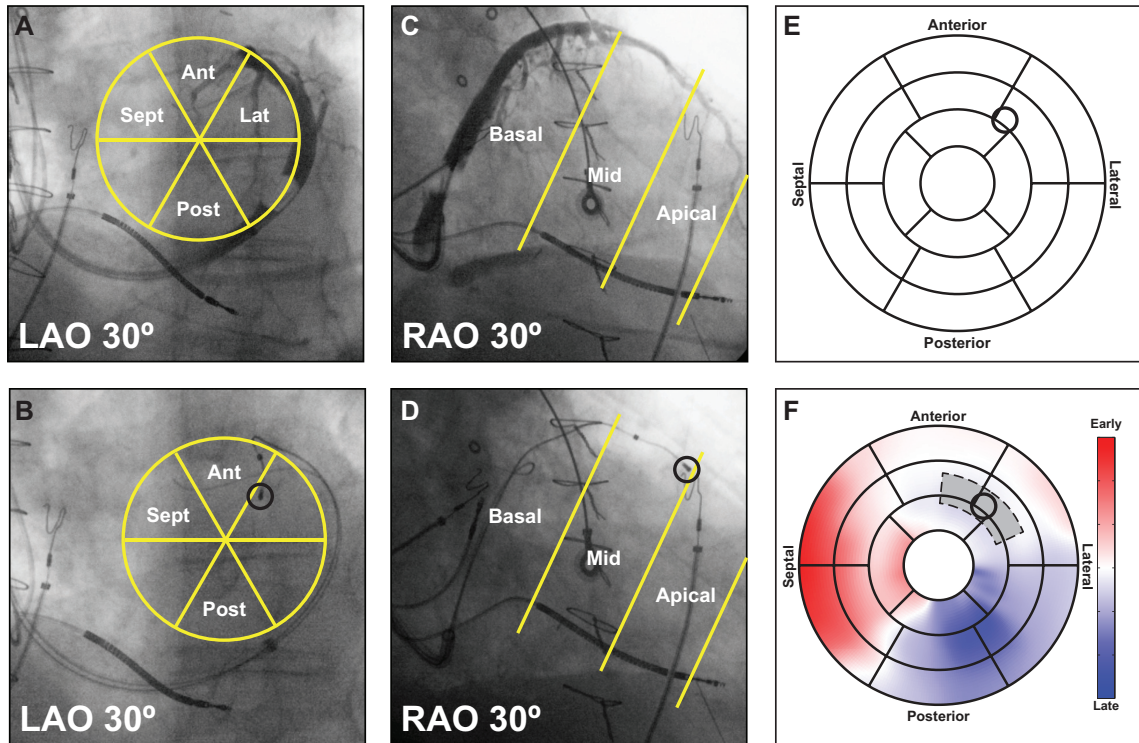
Dual-plane venograms (A, C) and lead localizing x-ray images (B, D) were used to map LV pacing lead locations (black circle) onto the AHA 17-segment model (E). LAO images were used to determine the circumferential location while RAO images were used for longitudinal position. Mechanical delay times in a region surrounding the lead location (shaded region) can be determined directly from the 17-segment model (F).
